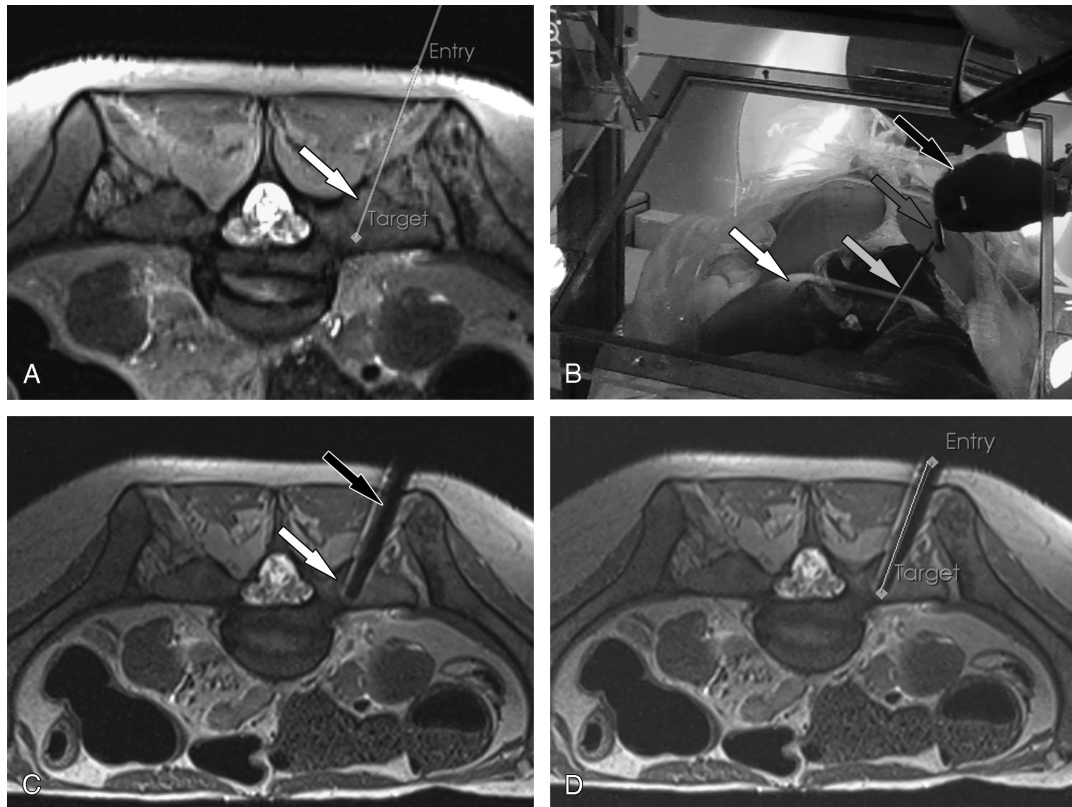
Image overlay navigated MR-guided biopsy of a right sacral osseous lesion: A, Axial T2-weighted MR image demonstrates the planned biopsy path (gray line) through an osseous lesion in the right upper sacrum (white arrow). B, Intraprocedural photograph of the operator view demonstrates the hybrid view of the subject and the projected MR image (white arrow), virtual biopsy path (light-gray arrow) through the right sacral lesion, the drill and the trocar (dark-gray arrow), and the operator's hand (black arrow). C, Axial intermediate-weighted turbo spin echo MR image after the drill placement demonstrates the drill (black arrow) through the target lesion (white arrow). D, Postprocedural assessment of the target error using the PerkStation module of the 3D Slicer software. The thick line indicates the planned biopsy path and the thin line indicates the actual biopsy path. The target error was 1.2 mm.
